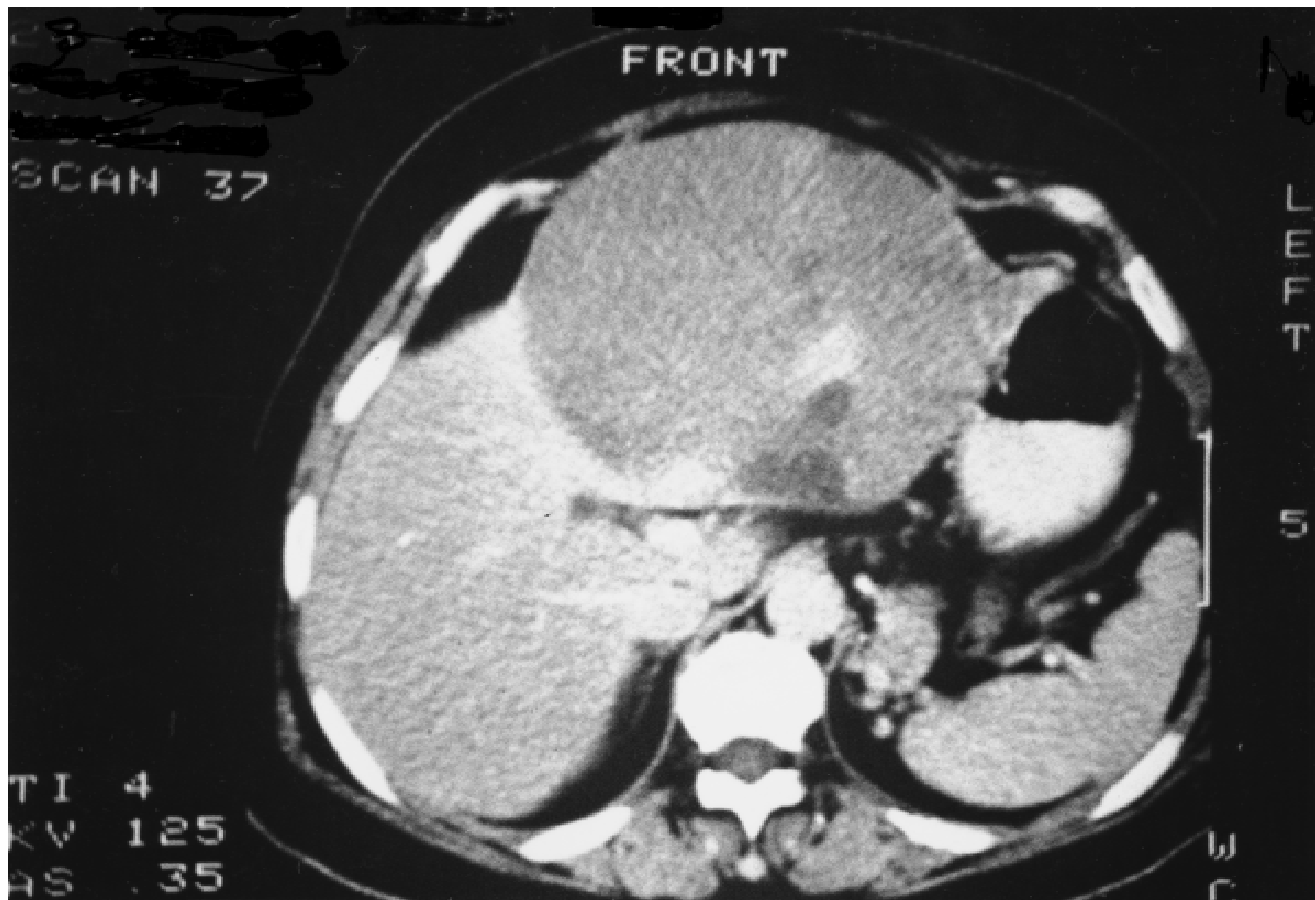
CT scan. Biliary cystadenocarcinoma appearing as a big multilocular cyst in the left lobe.
